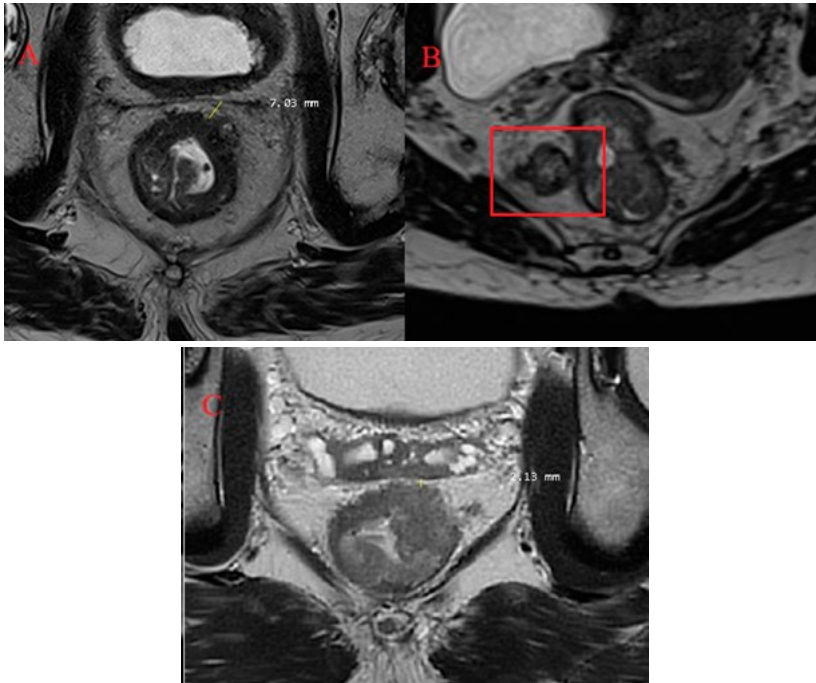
Representative MRI scans showing the involvement of the mesorectal fascia
